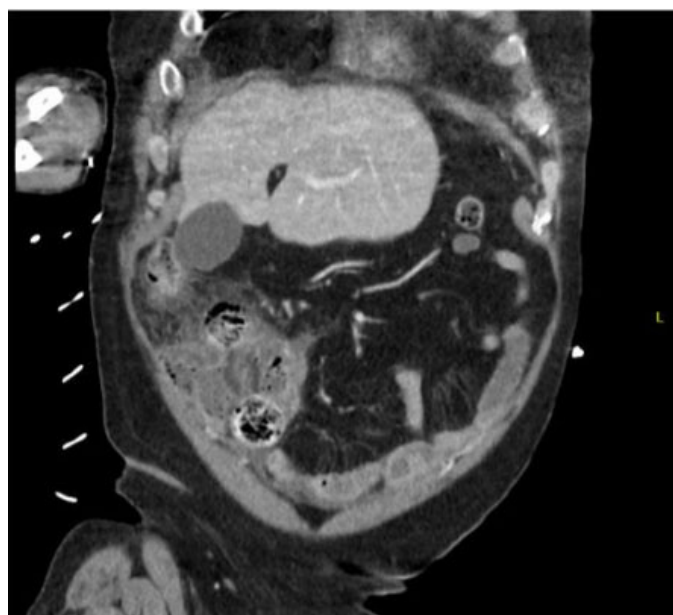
Coronal CT image demonstrating cecal diverticulum with feculent content and inflammation of the surrounding fat.
